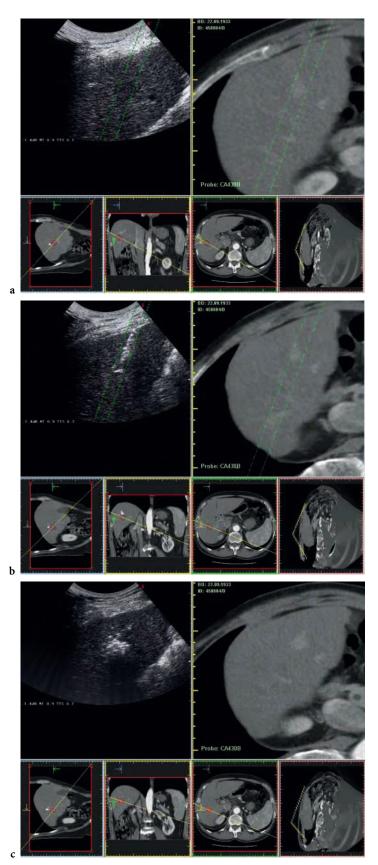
A multimodality fusion imaging system (Virtual Navigator System, Esaote SpA, Genoa, Italy)-real-time registration and fusion of pre-procedure CT volume images with intraprocedure US-used for a percutaneous radiofrequency ablation of an hepatocellular carcinoma: targeting of the lesion (a), needle placement (b) and evaluation of the ablation zone
